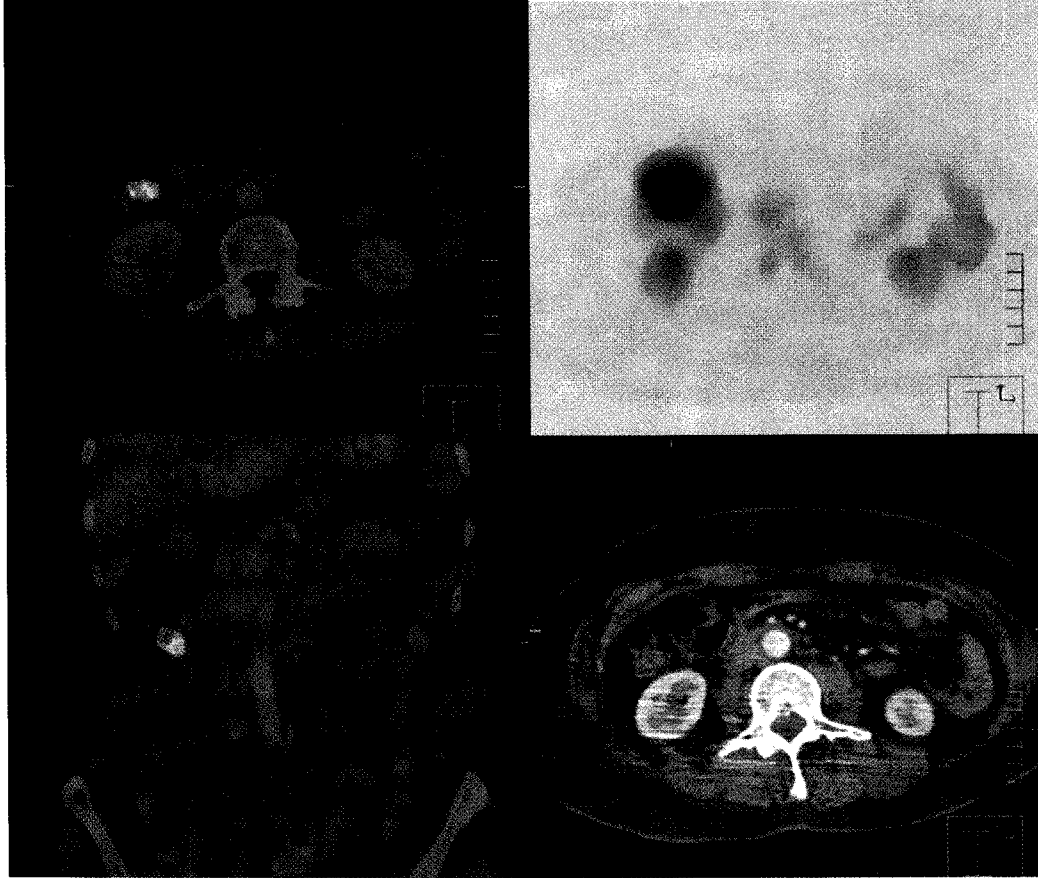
Coronal PET/CT, transaxial CT and transaxial PET/CT images from 64-year-old woman with GBM. Focal colonic FDG uptake was shown in Rt. colon on PET/CT images. Conventional abdominal CT scan, colonoscopy and follow up PET/CT scan were negative. Also the patients showed no evidence of disease after 3 months of follow up.
